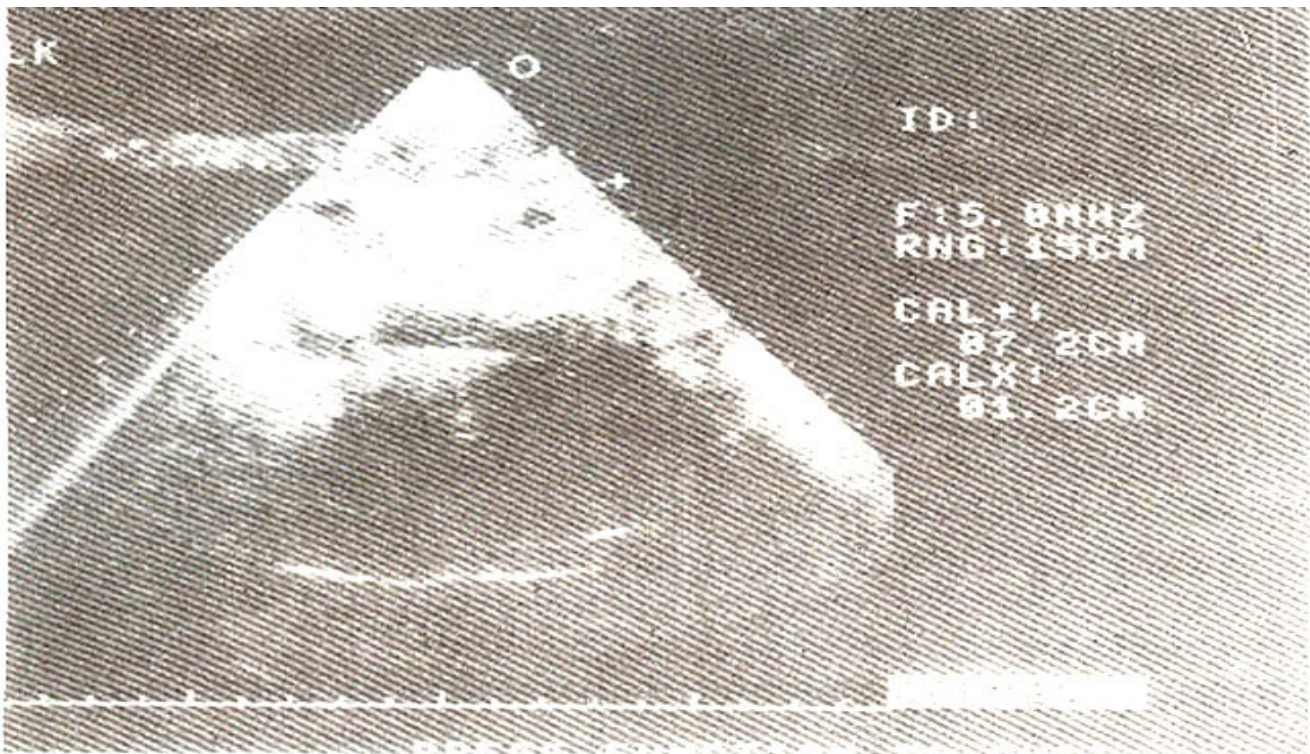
Ultrasound of the abdomen before therapy showing bilateral enlargement with increased echogenicity of renal parenchyma.
